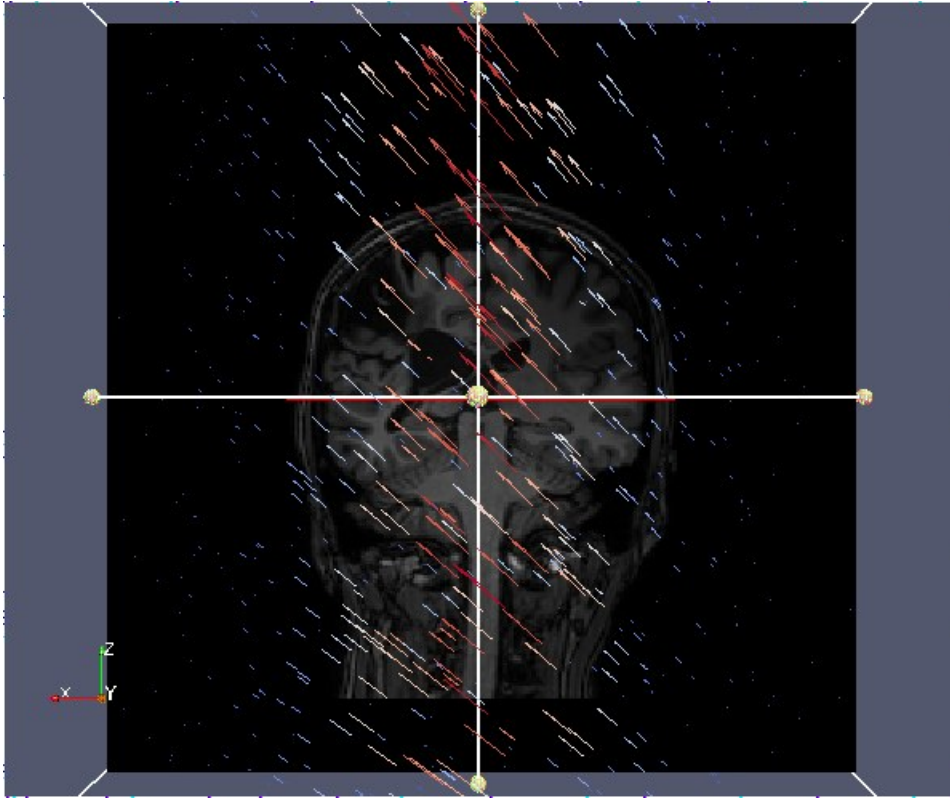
A brain MRI with the vector field used for the warping (arrows).
